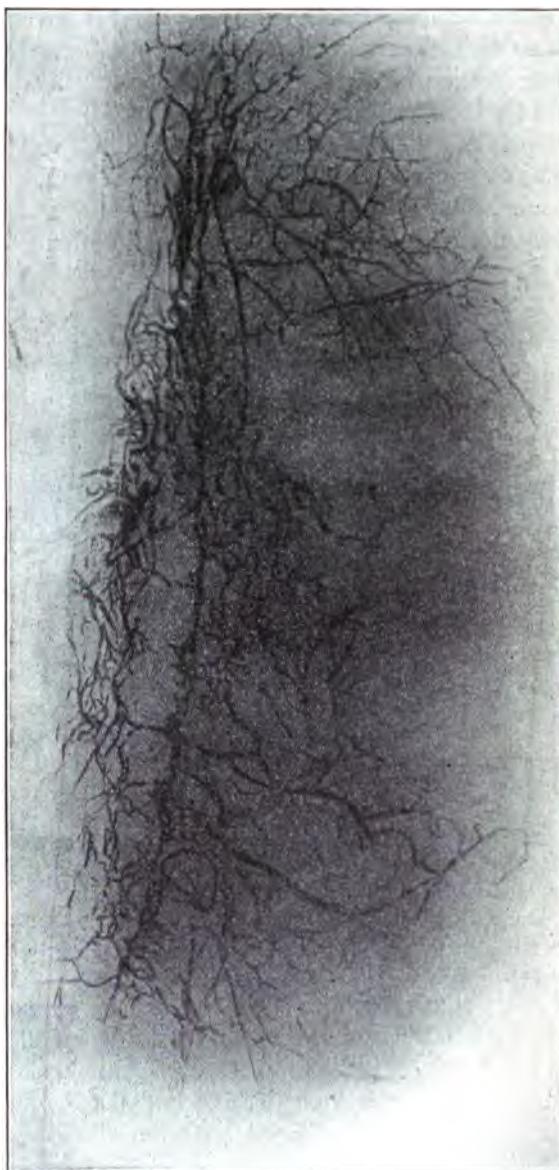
Retouched radiograph showing the collateral venous circulation after resection of the vena cava. (Draudt.)
